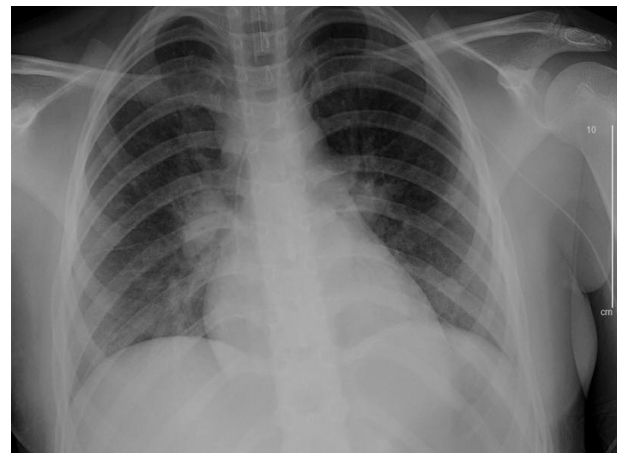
Chest X-ray, anteroposterior (AP) view after 7 days of remdesivir therapy (hospital day 15).
